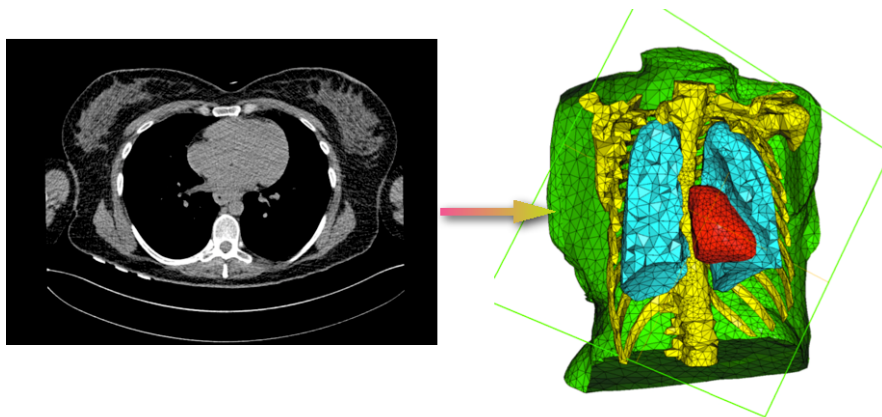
Mesh of a human torso and one of the X-ray computed-tomography slices on which it was based.
